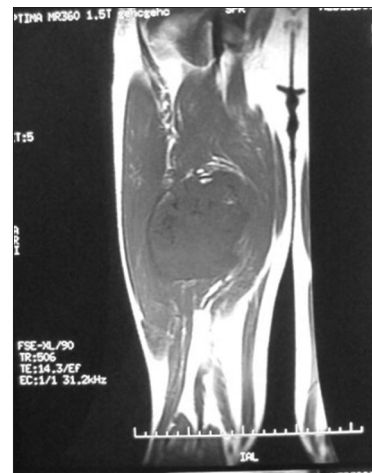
Magnetic resonance imaging of the right femur showing the tumour
